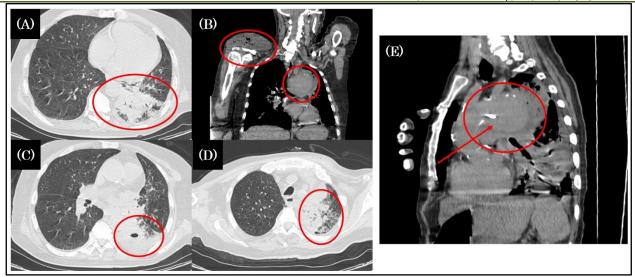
Follow-up chest CT showing progression of infectious and vascular complications (21 March 2025). (A, C, D) Axial images demonstrate worsening necrotizing pneumonitis with multilobar consolidation and enlarging cavitary nodules (red circles). (B) Coronal reconstruction highlights persistence of the right shoulder abscess with gas formation and interval increase in the size of the aortic arch aneurysm (red circles)
